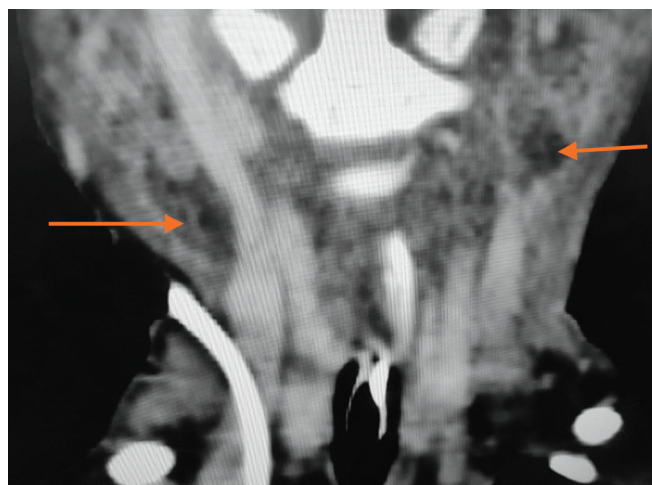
CT neck (coronal view) showing necrotic collections in neck
